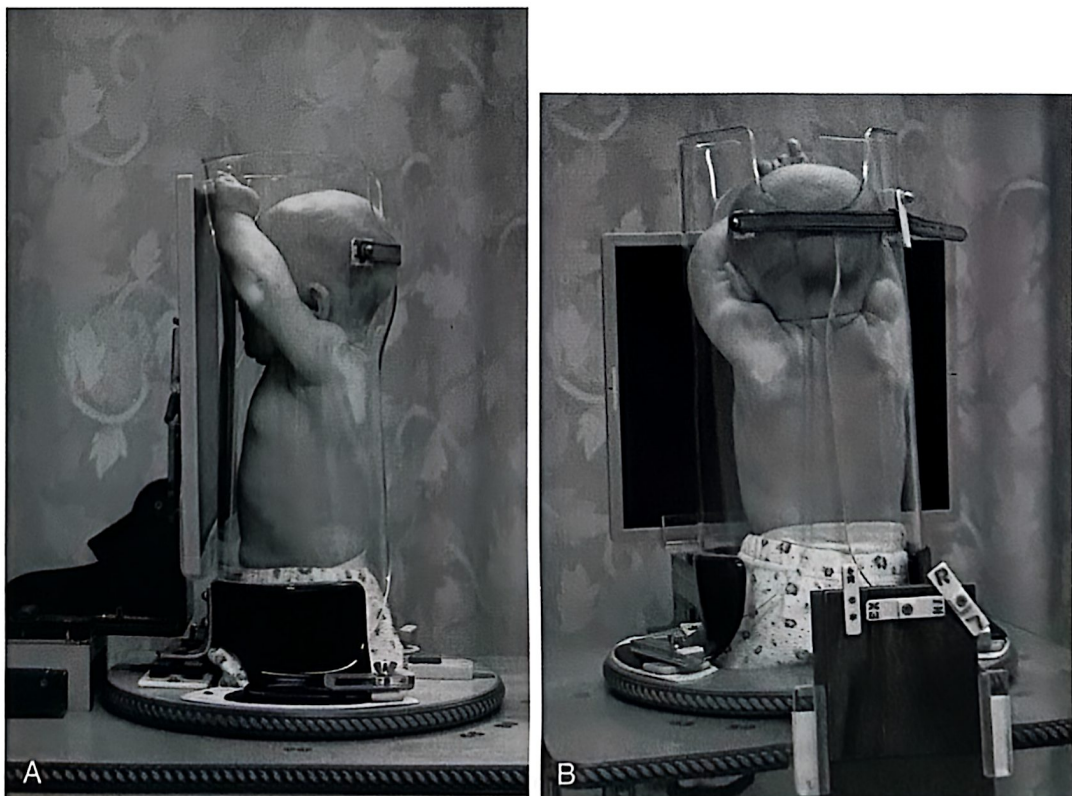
Pigg-O-Stat positioning chair for upright pediatric chest radiography.
